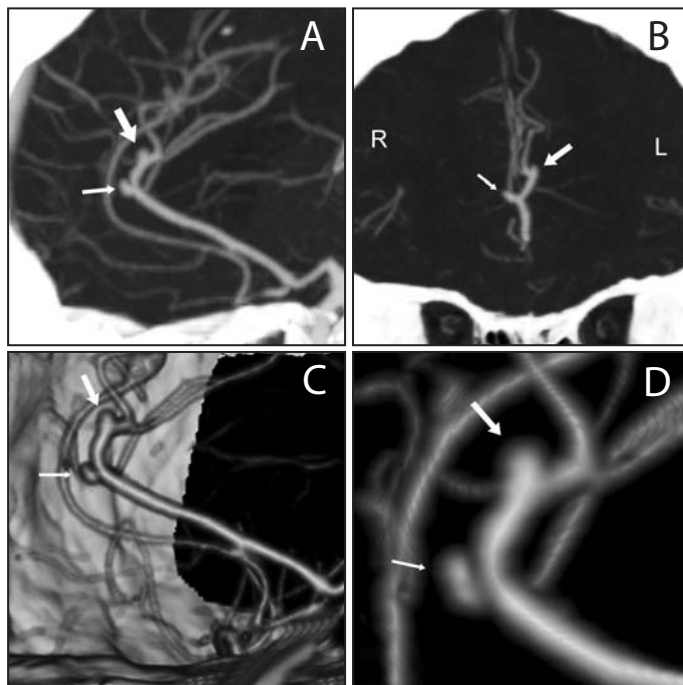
Unruptured anterior A3A (small arrow) and unruptured superior A3A found on the same pericallosal artery as seen on CTA in (A) sagittal view, (B) coronal view, (C and D) 3D reconstructions.
